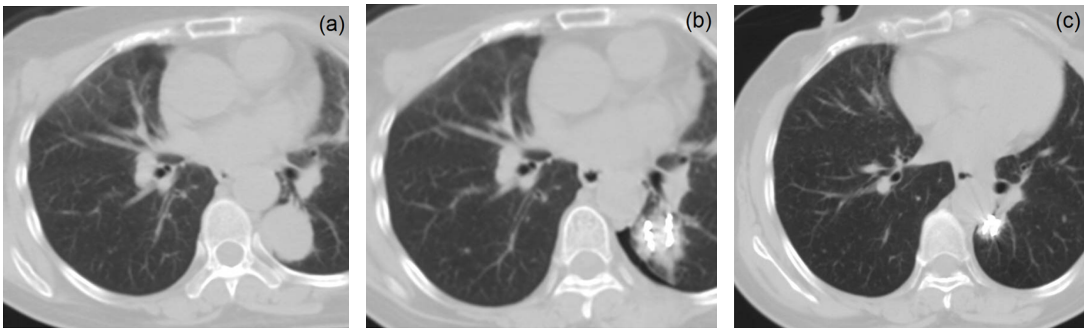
A typical case of ^{125}I brachytherapy and GP chemotherapy treatments: a 60-years-old man with squamous cell cancer located in the lower lobe of left lung, (a) The tumor was sized at 4.2 cm \times 4.0 cm. (b) Instant CT scan verification was made after implanting ^{125}I seeds and the verified dose was 116.8 Gy. (c) Six month after ^{125}I brachytherapy and GP chemotherapy, the lesion disappeared on the CT scan, only funicular shadow and the ^{125}I seeds left. The patient achieved complete response after the treatments.
